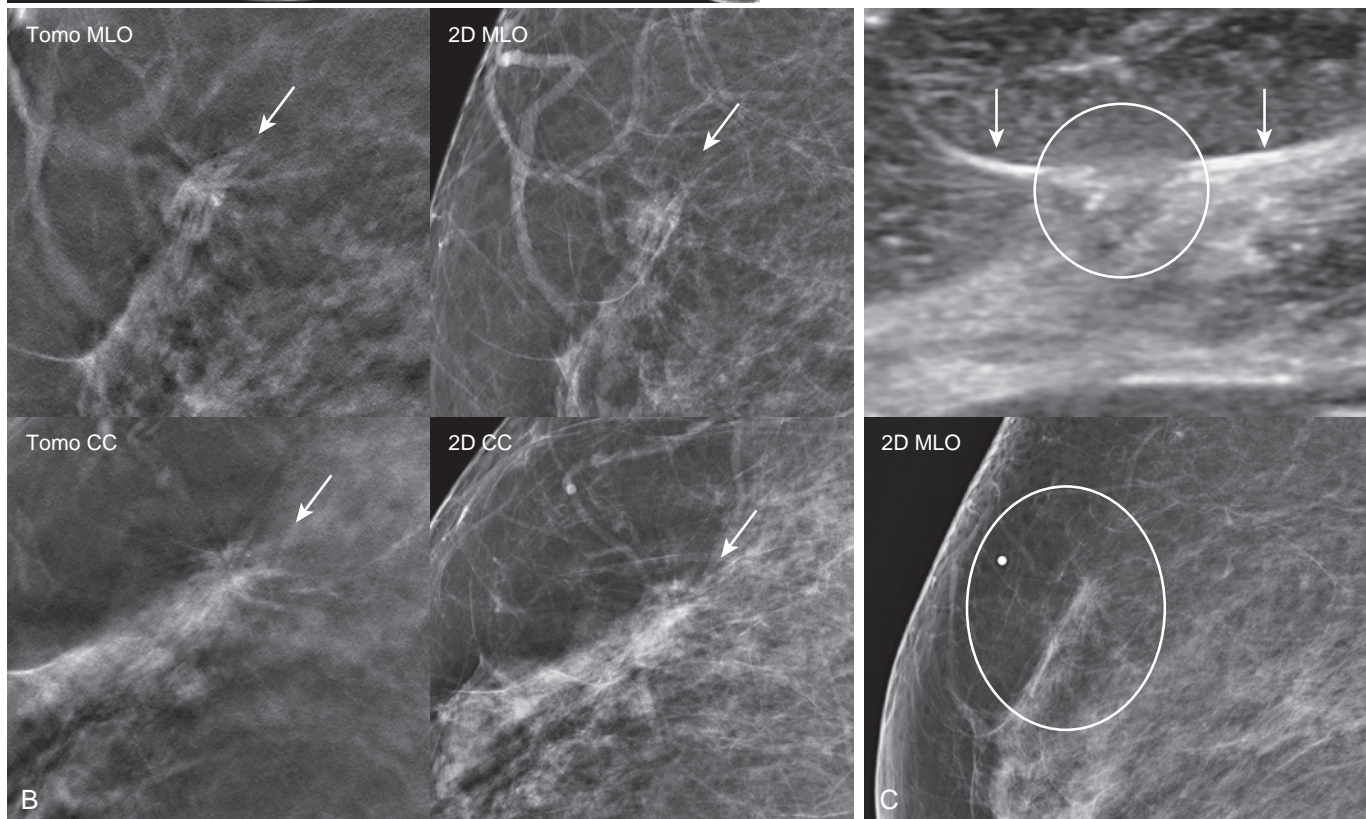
A BB marker can be useful in determining if a subtle ultrasound finding corresponds to a tomosynthesis architectural distortion. (A) 2D screening mammogram (right breast only) in a 67-year-old woman demonstrates scattered fibroglandular tissue and no suspicious findings. (B) Close-up corresponding tomosynthesis views reveals a subtle AD (arrows) in the upper outer quadrant, which is seen only on retrospect on the 2D views where the spiculations are not apparent. (C) Targeted ultrasound demonstrates a very subtle corresponding isoechoic mass with associated straightening of adjacent Cooper ligaments (arrows) in the right breast at 11 o'clock. A BB marker was placed over the mass on ultrasound and a spot compression 2D MLO view confirmed mammography/ultrasound correlation (circle). Ultrasound-guided core needle biopsy = Lobular carcinoma in situ, grade 3 with necrosis. Surgical excision = invasive tubular carcinoma (1 cm) associated with a complex radial sclerosing lesion, ER/PR+/Her2-, 0/2SLN.
